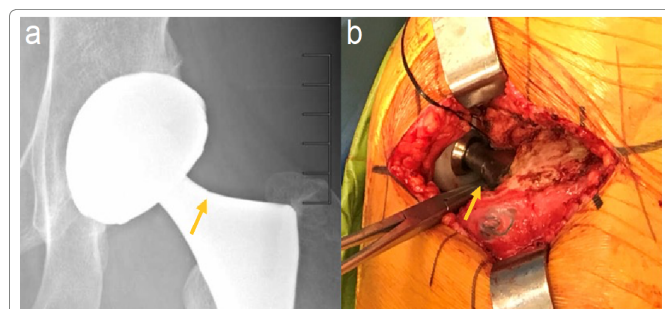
Case 1: Pre-revision anteroposterior radiograph showing neck stem notching (a). Notching on the superior aspect of the femoral neck seen intra-operatively (b).
